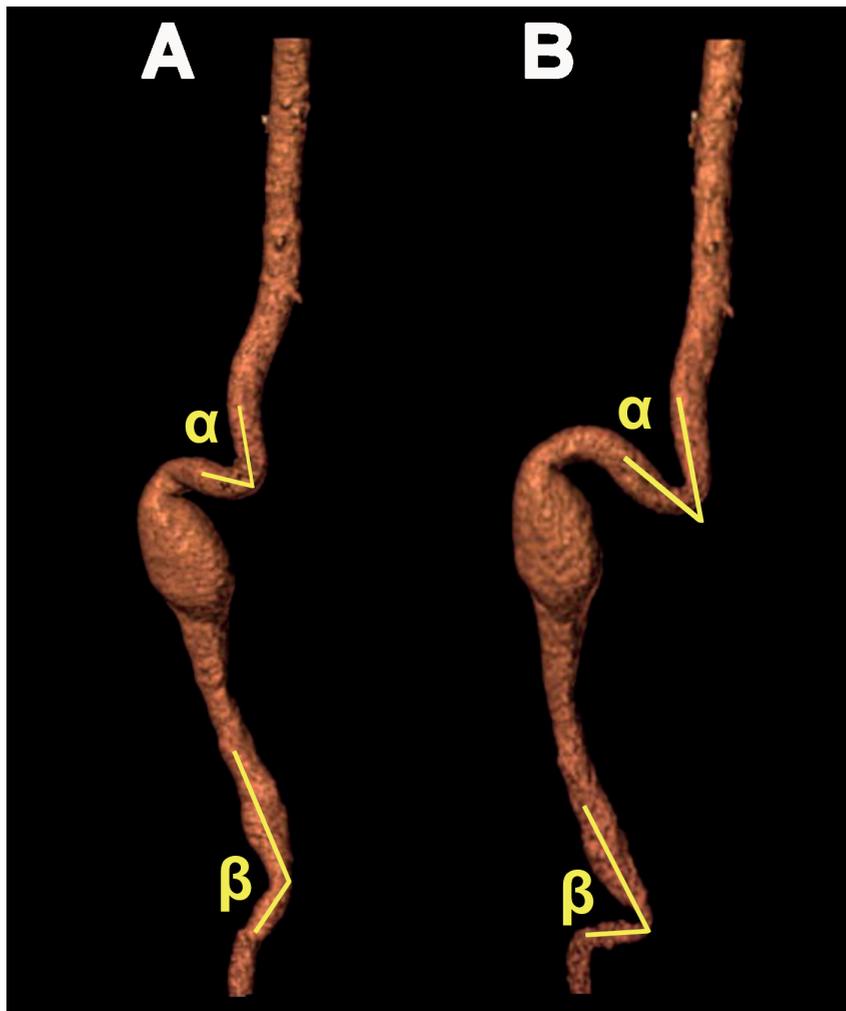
CTA scan of a popliteal artery aneurysm after multiplanar reconstructions of the center lumen line. A extension, B 90° flexion. (α) is the angle between the longitudinal axis of the normal popliteal artery proximal to the aneurysm and the longitudinal axis of the PAA sac. (β) is the angle between the longitudinal axis of the PAA sac and the longitudinal axis of the normal popliteal artery distal to the aneurysm
